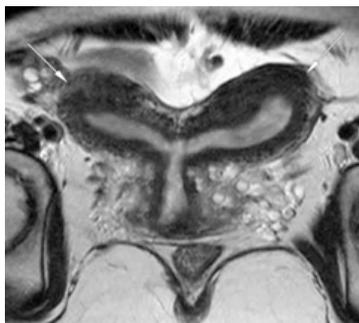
MRI showing Uterus didelphys*
